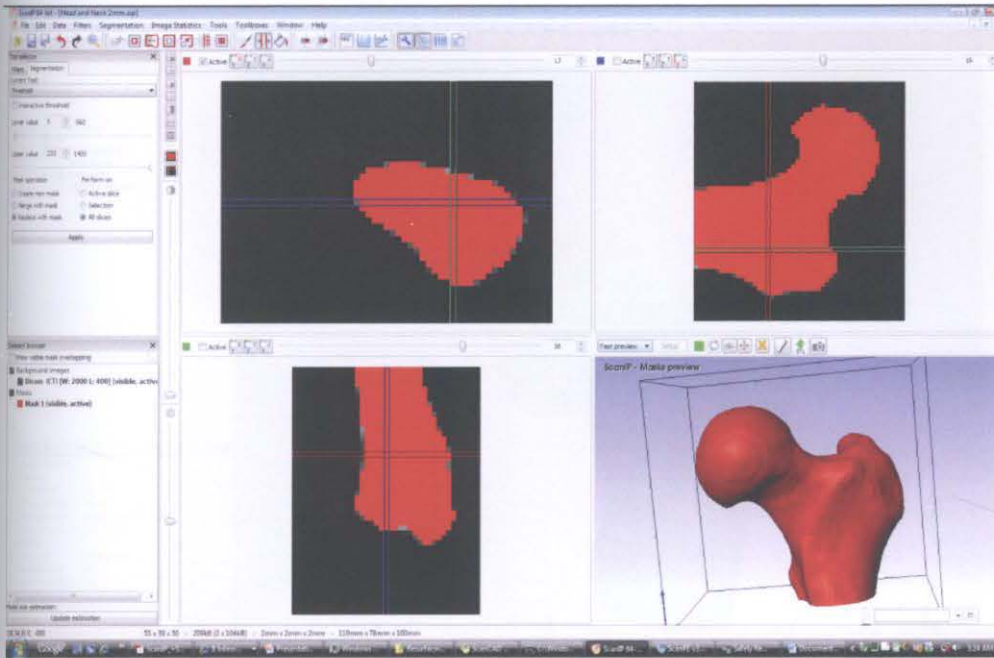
Proximal geometry of femur segmented from CT scan viewed in Simpleware
